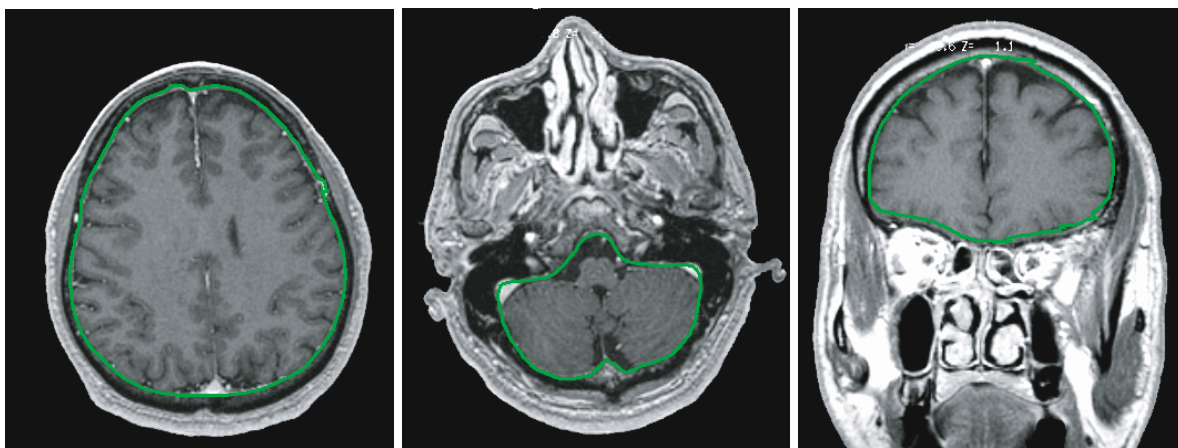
Image-geometry visual validation structure overlay of CT-defined brain outlines (green) over MR images
